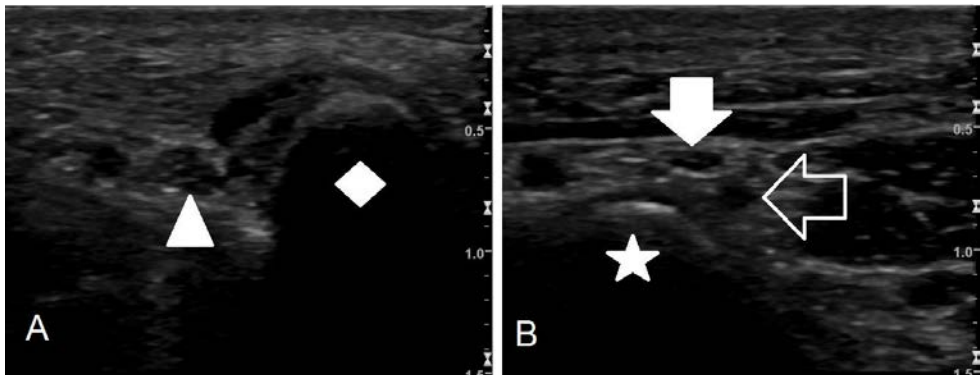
(A, B) Transverse high-resolution ultrasound image of the ulnar nerve within Guyon's tunnel in (A) Zone 1 and (B) Zones 2 and 3. The fascicular pattern of the ulnar nerve (solid white arrowhead in A) can be discerned adjacent to the pisiform (solid white diamond in A). In B, the superficial sensory branch can be seen (solid white arrow), and the deep motor branch (open arrow) begins to reflect around the hook of the hamate (solid white star).
